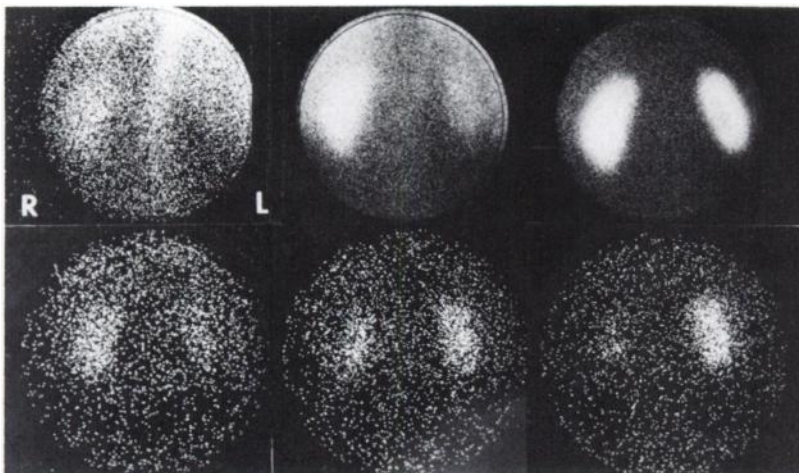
Forty-four-year-old male with antihypertensive hypertension and left renal artery stenosis, eventually treated by nephrectomy. Renal scintigraphy: upper row—Tc-99m glucoheptonate images at 18 sec, 1 min, and 1 hr. Impaired concentration in left kidney is most obvious at 1 min. Lower row— ^{131}I Hippuran 2-min images at 1, 10, and 30 min. Left renal concentration is decreased initially, but later is increased due to prolonged parenchymal retention.
